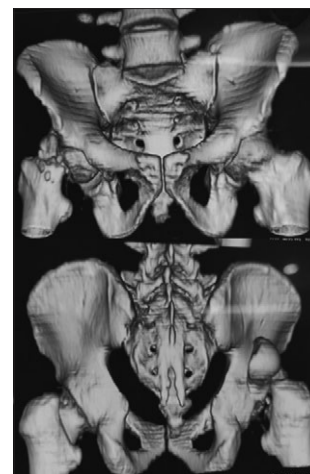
Noncontrast CT (3D reconstruction) of the pelvis with both hips showing anterior and posterior views. 3D: Three-dimensional, CT: Computed tomography
